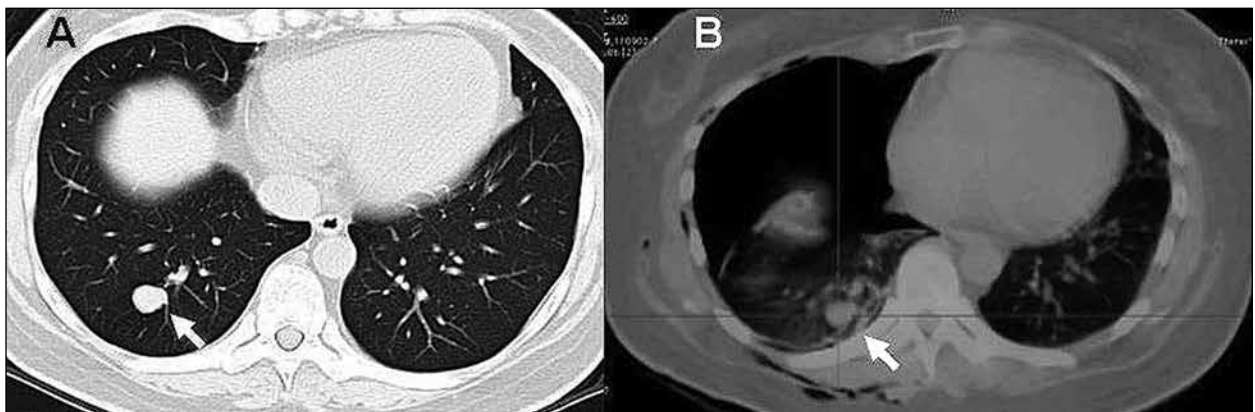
(A): Chest CT scan: nodular lesion 1.5 centimeter (cm) in the right lower lobe of lung (white arrow), (B):  $^{18}\text{F}$ -FDG PET: FDG uptake within the primary tumor (white arrow) (maximum standardized uptake value, 2.4)
